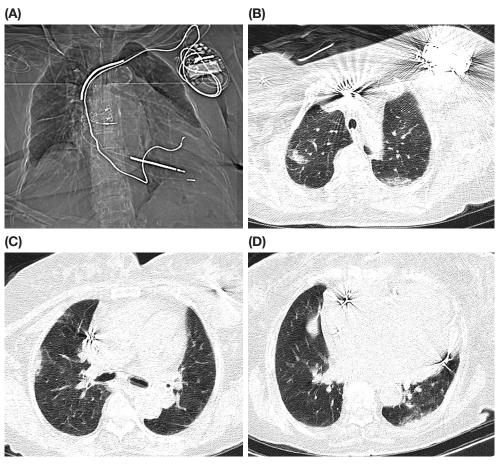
A 79-year-old, non-diabetic woman with heart failure, suggested by a large heart (CT ratio>60%) and cardiac resynchronization therapy leads in place on topogram image (A) and large intrapulmonary arteries (broncho-arterial ratio<0.5) (D), showed mild lung involvement in the form of small peripheral foci of mixed GGO and consolidation in her first-day in-hospital CT (B-C) with CTSS1= 6/24, CTSS2= 12/48, CTSS3= 5/20, CTSS4= 5/25, CTSS5=6/30, CTSS6= 5/20, CTSS7= 14/40. She presented with moderate disease which progressed to severe disease with ICU admission after 2 days and further progression to intubation (critical disease) after another day and died the next day (critical outcome).
